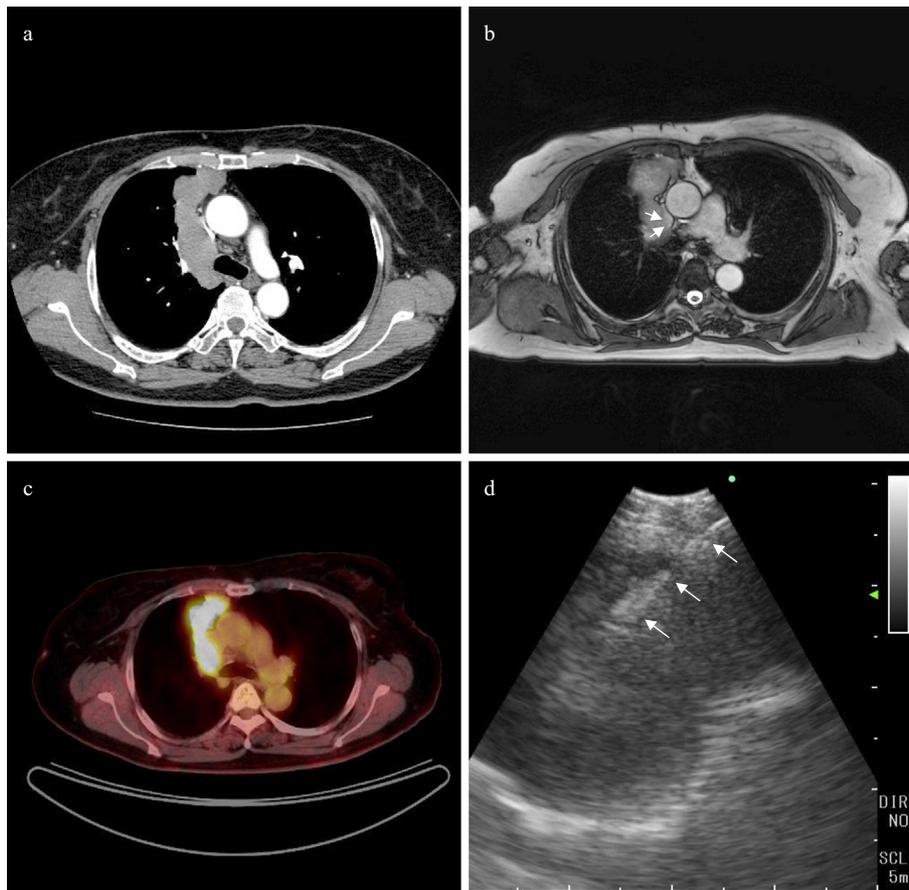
Case 1. a: Contrast-enhanced chest CT showing a homogeneous mediastinal tumor adjacent to the trachea. b: An axial T2-weighted MR image of the chest showing a mediastinal tumor with irregular margin and heterogeneous intensity and invasion into the superior vena cava (arrows). c: A PET/CT scan showing the remarkable FDG uptake in the tumor. d: Endobronchial ultrasound showing needles (arrows) penetrated through a mediastinal tumor with heterogeneous echogenicity.
